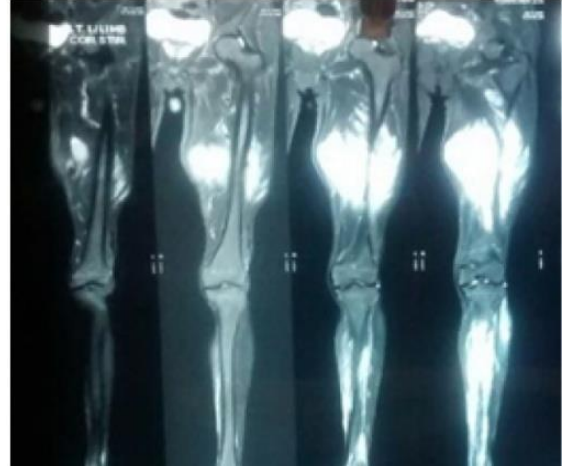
MRI Heterogeneously enhancing multi lobulated predominantly solid large mass lesion occupying the medial and posterior compartment of the left thigh extending from the neck of the femur till the mid thigh and with a track extending to the leg. The mass in the leg occupies the posterior compartment of the leg displacing the muscles anteriorly and posteriorly and extending into the lateral compartment posterior to the femur. Another track from the lower end of the mass extending till the ankle joint. Possibility of soft tissue sarcoma with local spread has to be considered above
